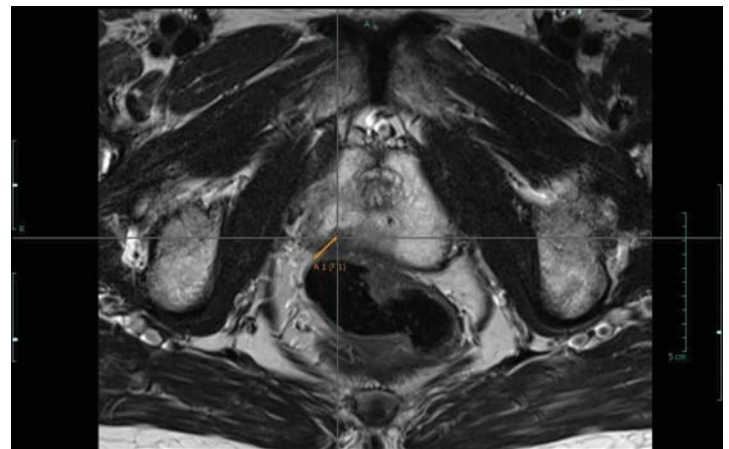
T2-weighted axial image highlighting area of suspicion
